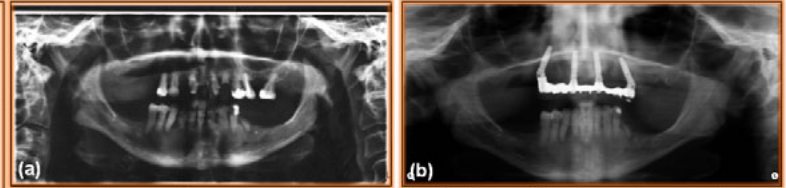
a. Preoperative orthopantomography; b. Postoperative orthopantomography.
